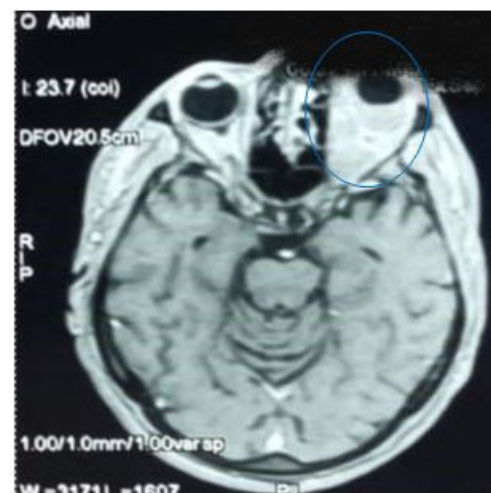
Magnetic resonance imaging (MRI) showed an intraconal soft tissue mass, oval, and poorly limited.
